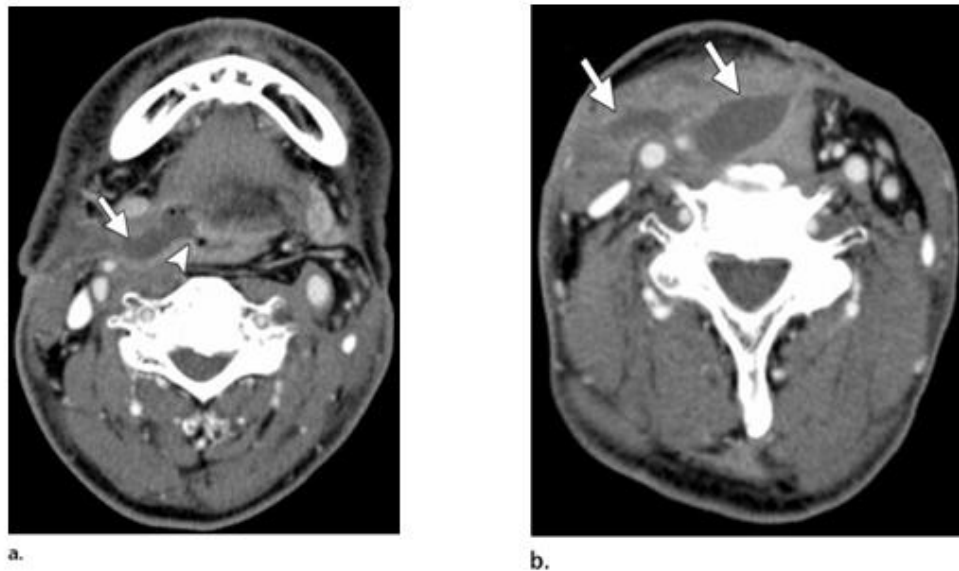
Fistula and abscess after irradiation and surgery in a 61-year-old man with right-sided modified neck dissection with flap reconstruction were performed. Axial contrast-enhanced CT images (obtained at the level of the base of the tongue and b at the lower neck level) show a fluid collection (arrows) with air adjacent to the surgical site and the flap. Note the formation of a pharyngeal fistula (arrowhead in a).
